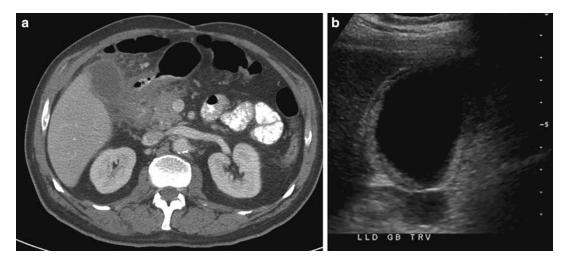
Acalculous cholecystitis. CT demonstrates wall thickening and irregular enhancement of gallbladder. US shows wall thickening but no gallstones are seen
